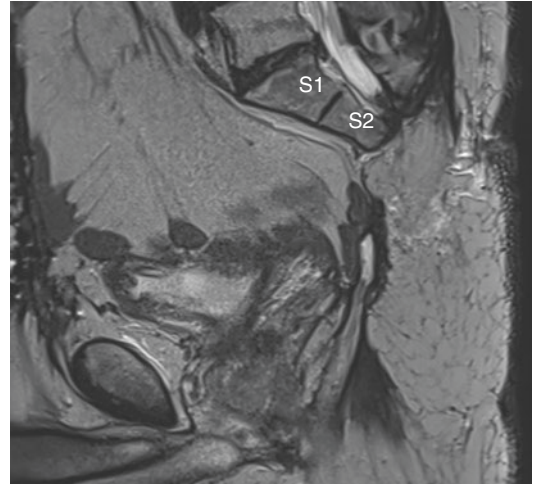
Sagittal MRI scan of an S3–S5 sacrectomy. The remaining S1 and S2 sacral segments have been marked out
